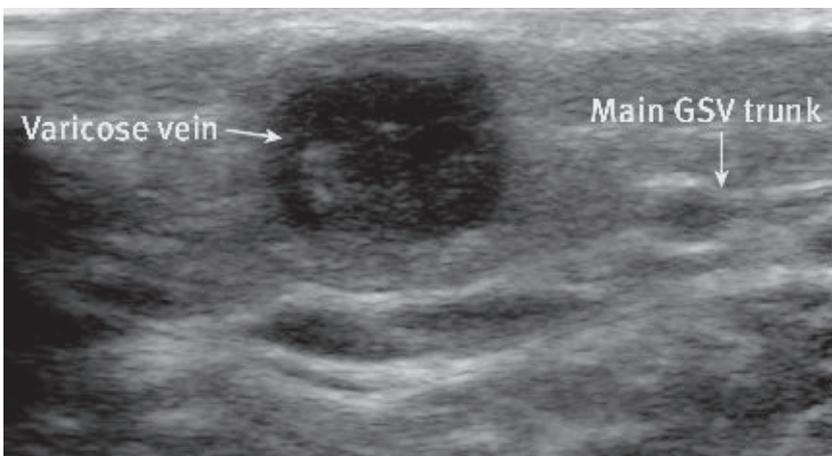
Typical duplex ultrasound appearance of superficial phlebitis involving a varicosity arising from the great saphenous vein (GSV). Note the echogenic material within the varicose vein
